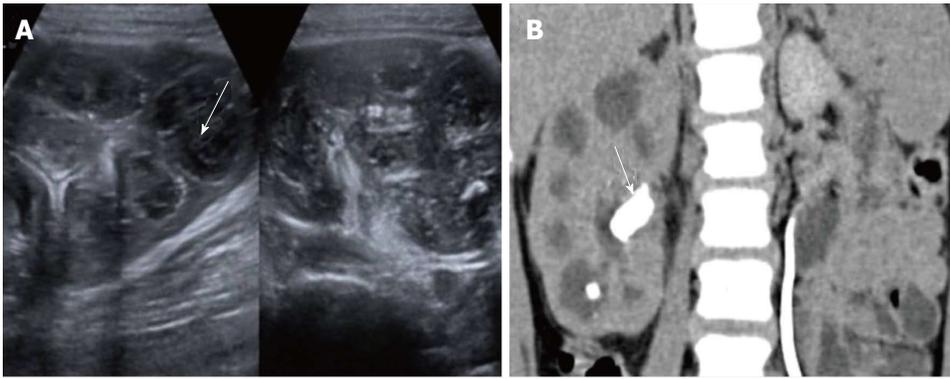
Xanthogranulomatous pyelonephritis. A: USG shows enlarged kidney with parenchyma replaced with multiple hypoechoic masses (arrow, A) comprising inflammatory exudate; B: Computed tomography shows multiple low-attenuation rounded masses, corresponding to either dilated calyces or focal areas of parenchymal destruction with a central staghorn calculus (arrow, B).
